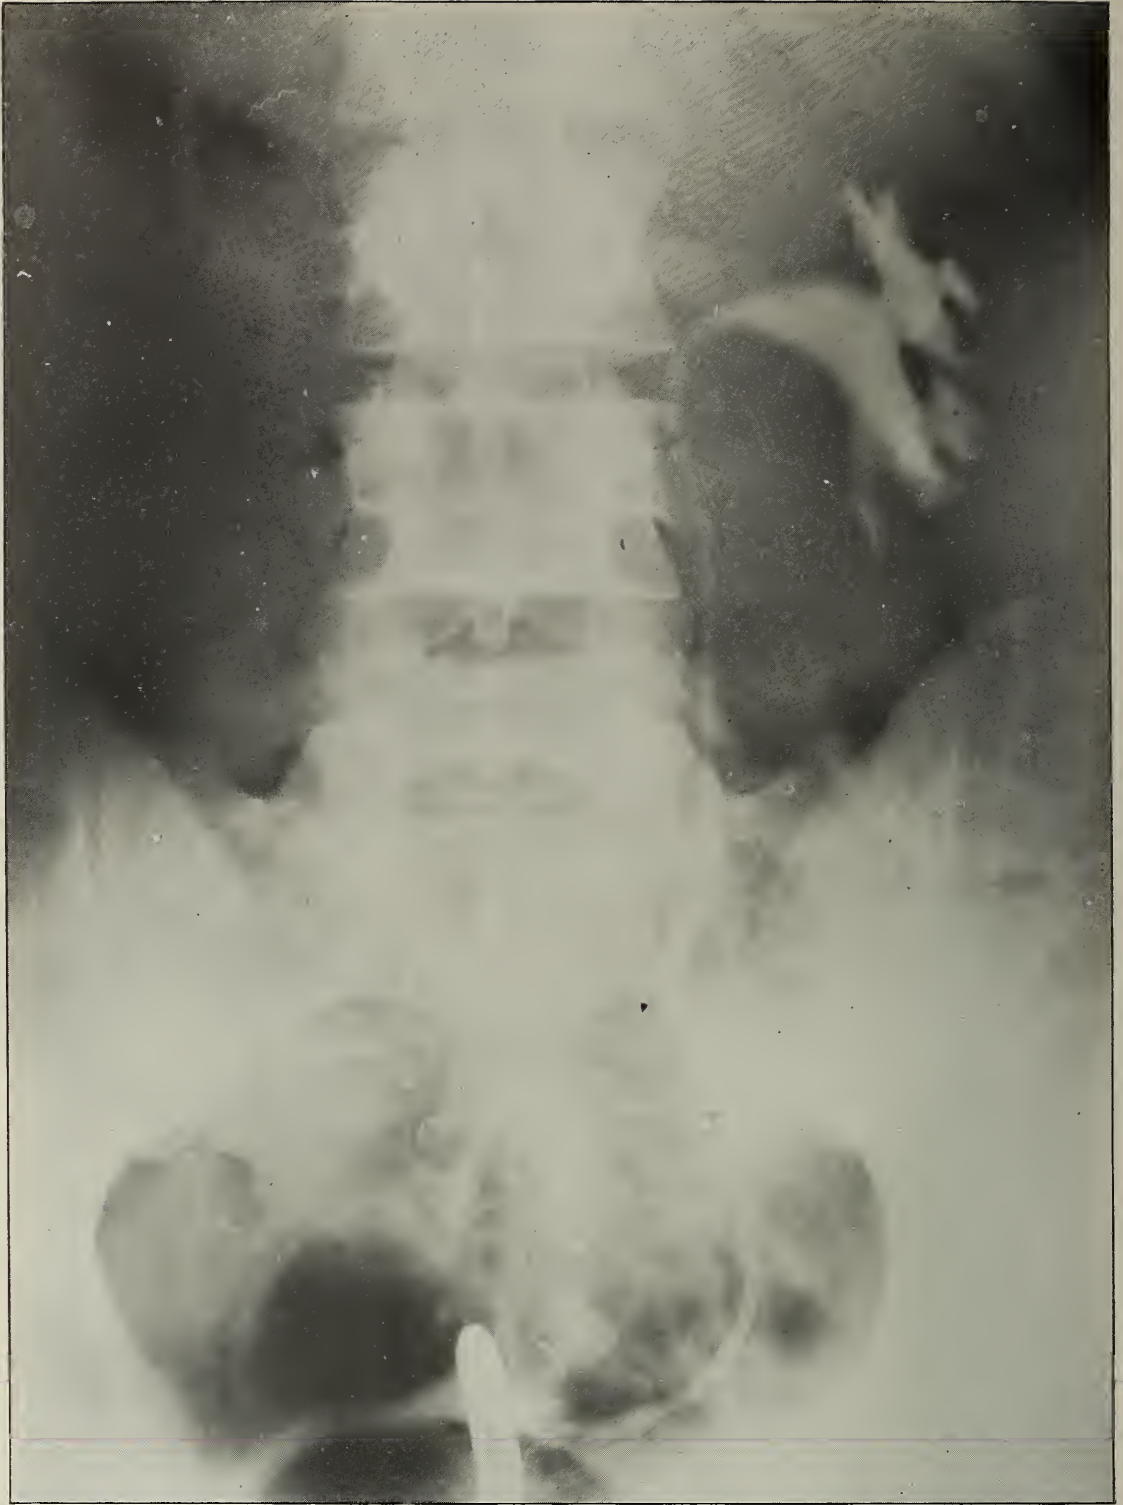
X-ray No. 9679. Region: abdomen and pelvis. Colloidal silver injection outlines a carefully injected renal pelvis and ureter, with full but not over distention of either calyces, pelvis or ureter.
